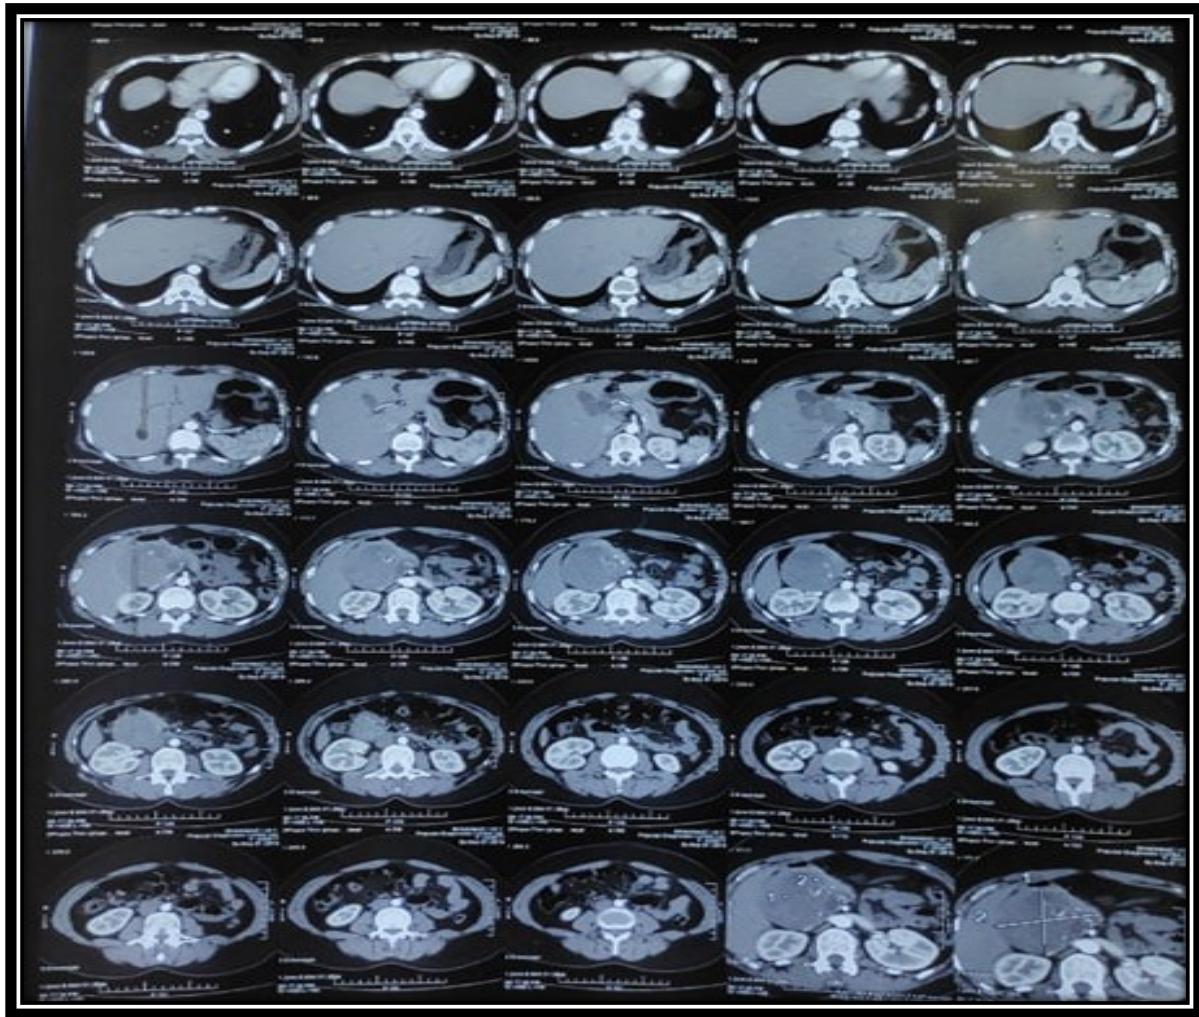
CT scan of abdomen showing a mass in the pancreatic head region
